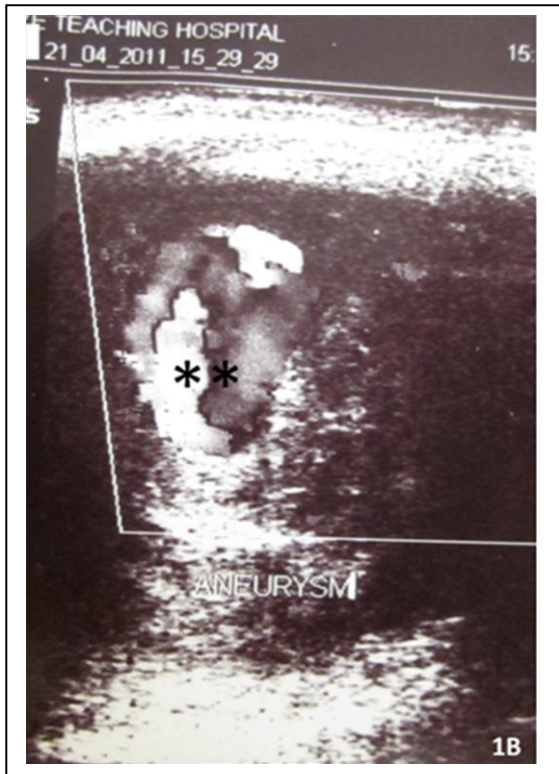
Doppler ultrasound image showing turbulent flow (*) within the pseudoaneurysm
